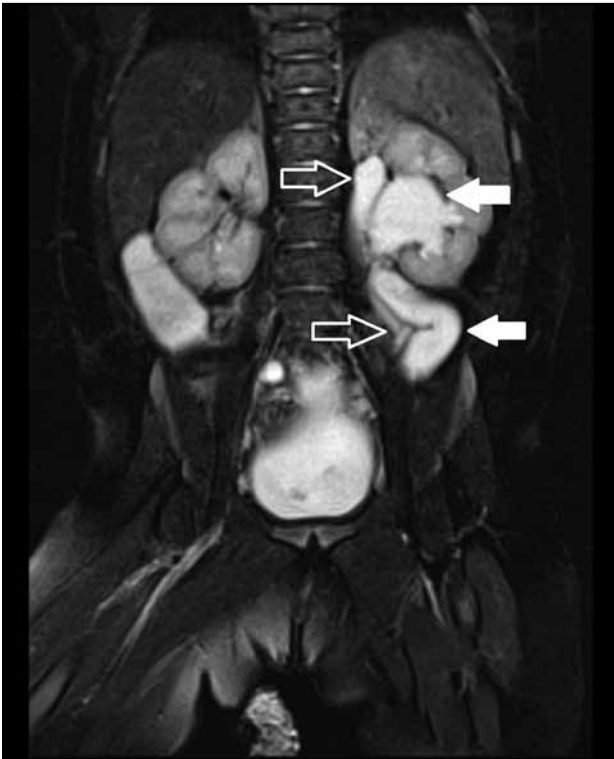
Patient A. Static coronal magnetic resonance urogram image in fat-suppressed T2-weighted turbo spin echo sequence showing the left duplex kidney with dilated pelvicalyceal system and ureters; the lower moiety renal pelvis and ureter are indicated by the white arrows while the upper moiety renal pelvis and ureter are indicated by the empty white arrows.
